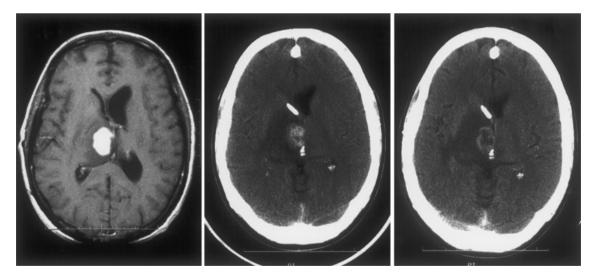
Metastatic large cell lung carcinoma. Gadolinium enhanced T1 weighted axial MRI from day of treatment (left), and contrasted enhanced axial CT scans from 2 (center) and 5 (right) months after radiosurgery for a recurrent metastatic large cell lung cancer, treated with 15 Gy to the 82% isodose surface of a 10.9 cc mass. The lesion has regressed in size and lost its central enhancement, but has not disappeared.
